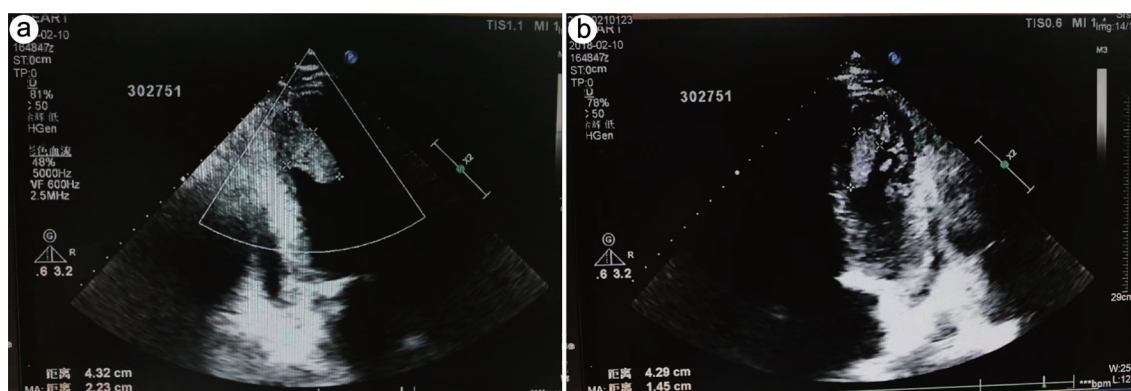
Admission UCG of case 2. UCG, ultrasonic cardiogram.
